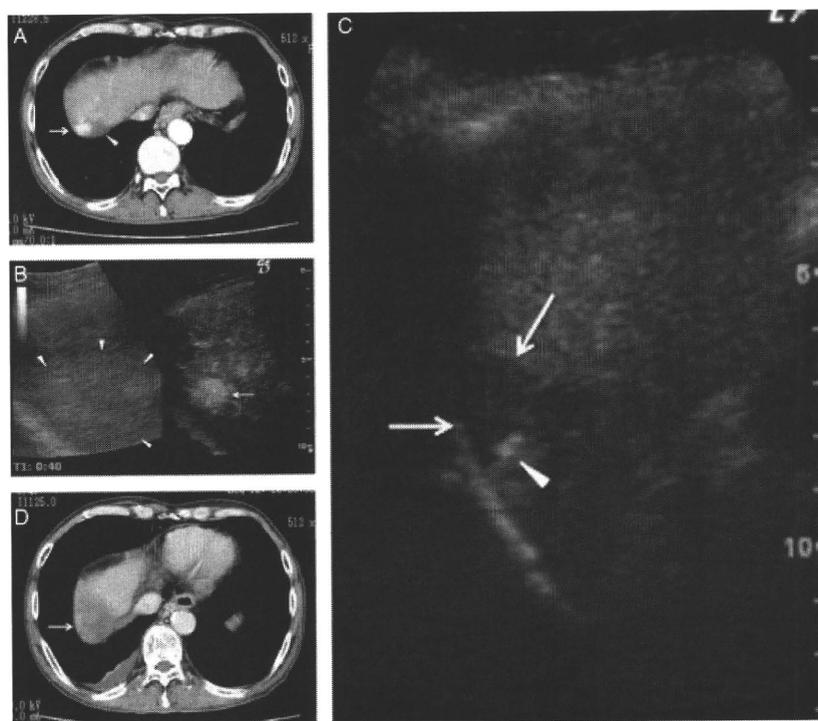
A 70-year-old man with 2.0 cm local tumour progression of hepatocellular carcinoma (HCC) after percutaneous radiofrequency (RF) ablation about 1 year ago. (A) Early-phase dynamic computed tomography (CT) scan shows local tumour progression of HCC as an enhanced lesion (arrow) in segment 7 of the liver. Surrounding area that was previously treated is not enhanced (arrowhead). (B) Right: Contrast harmonic sonography shows enhancement of viable HCC focus (arrow) in the early vascular phase after administration of perfluorocarbon microbubbles. Left: A high echoic area (arrowheads) contains both a viable HCC lesion and a necrotic ablation area on B-mode sonography. (C) Contrast harmonic sonography shows the defect (arrows) imaging in the post-vascular phase and RF electrode (arrowhead) needle inserted. The RF electrode was placed through the right side of the tumour, and then the left side of the tumour was ablated after the second penetration of the RF electrode after the first ablation. (D) Early-phase dynamic CT scan obtained three days after RF ablation therapy shows that the tumour and the surrounding area (arrow) are not enhanced.
